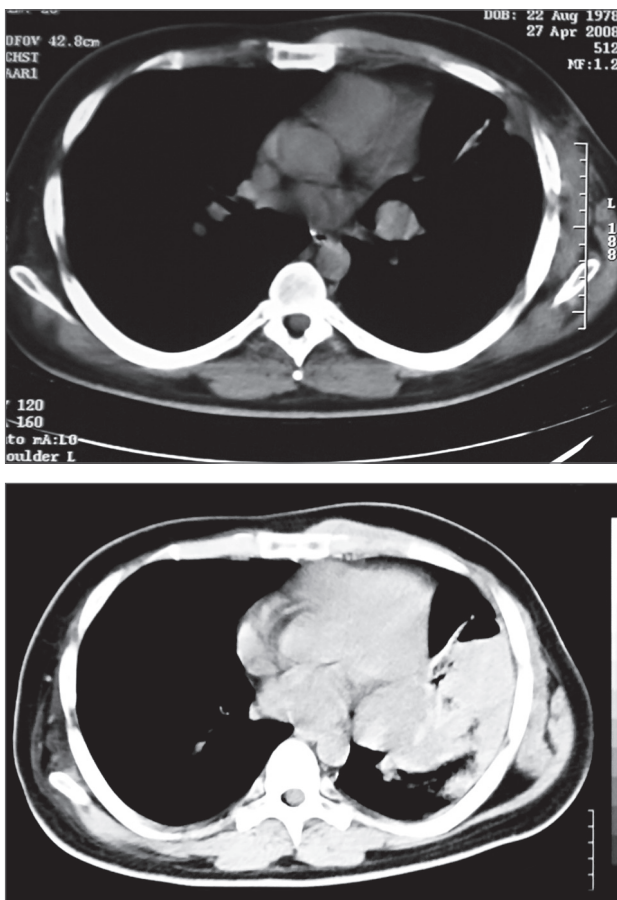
Case #1: CT scans show the growth of a lung metastatic lesion in less than one month and after one cycle treatment with trabectedin.
